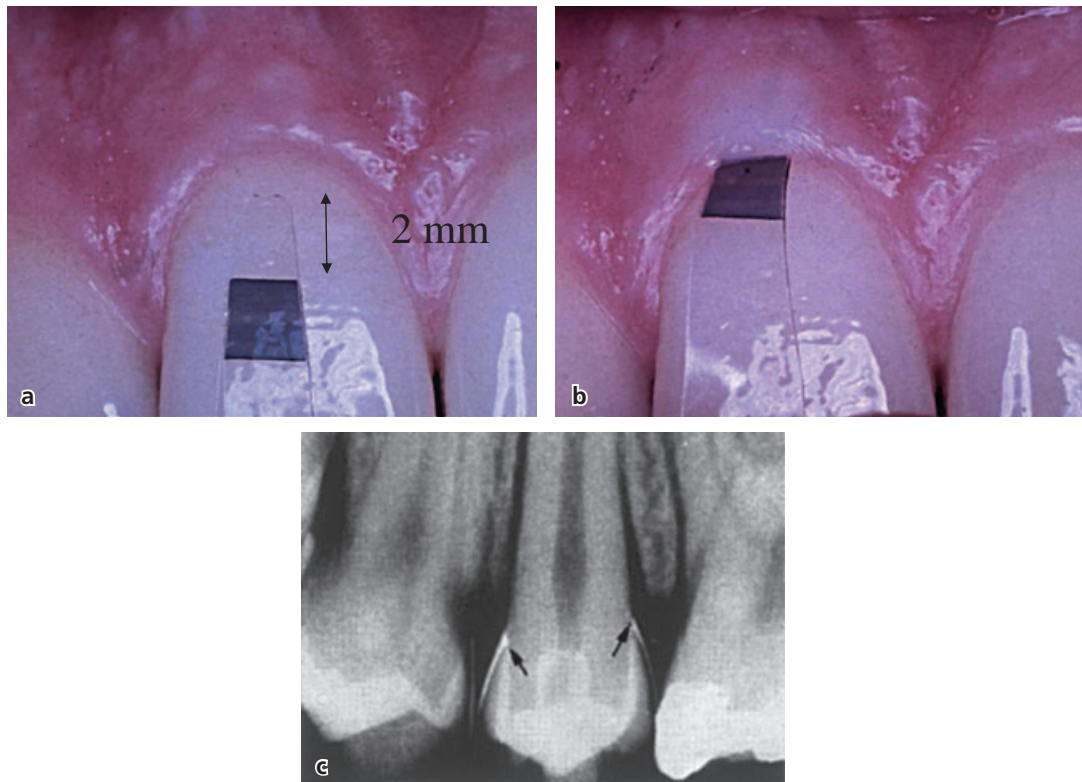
An acrylic strip with a blue zone located 2 mm from the strip margin (a) prior to and (b) after its insertion into a buccal “pocket”. The strip could with a light force be inserted 2 mm into the “pocket”. (c) Thin blades of steel were inserted in pockets at approximal sites of teeth with healthy periodontal conditions. In radiographs, Waerhaug (1952) could observe that the blades consistently reached the cemento-enamel junction.
